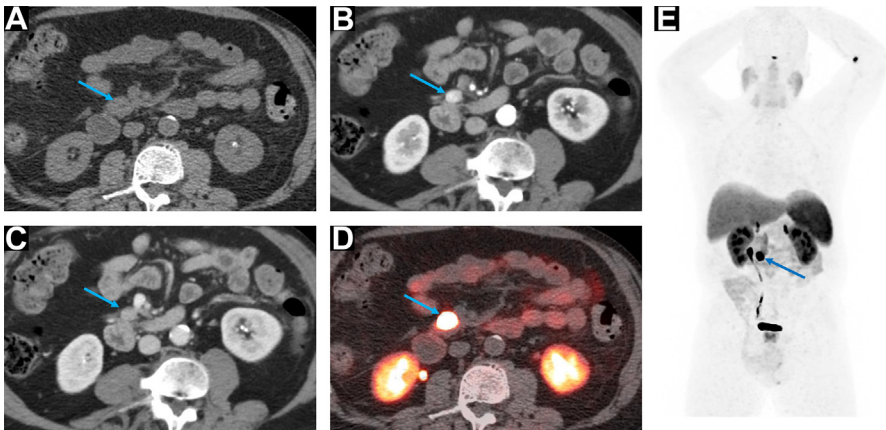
PNET (arrows) on multiphase contrast-enhanced CT of the abdomen: precontrast (A), arterial (B), and portal venous (C) phases, demonstrating arterial hyperenhancement with subsequent washout. ^{64}Cu -DOTATATE PET/CT axial fused (D) and maximum intensity projection (MIP) (E) images show intense uptake in the lesion and no evidence of metastatic disease.
